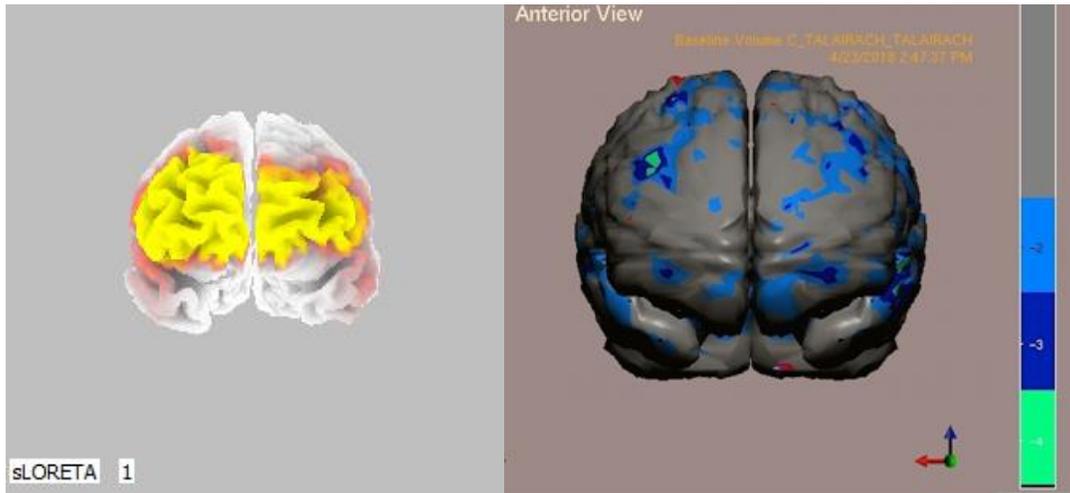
The 1.5Hz source localization corresponds with individually variable NRF SPECT patchy hypoperfusion over the prefrontal cortices.
